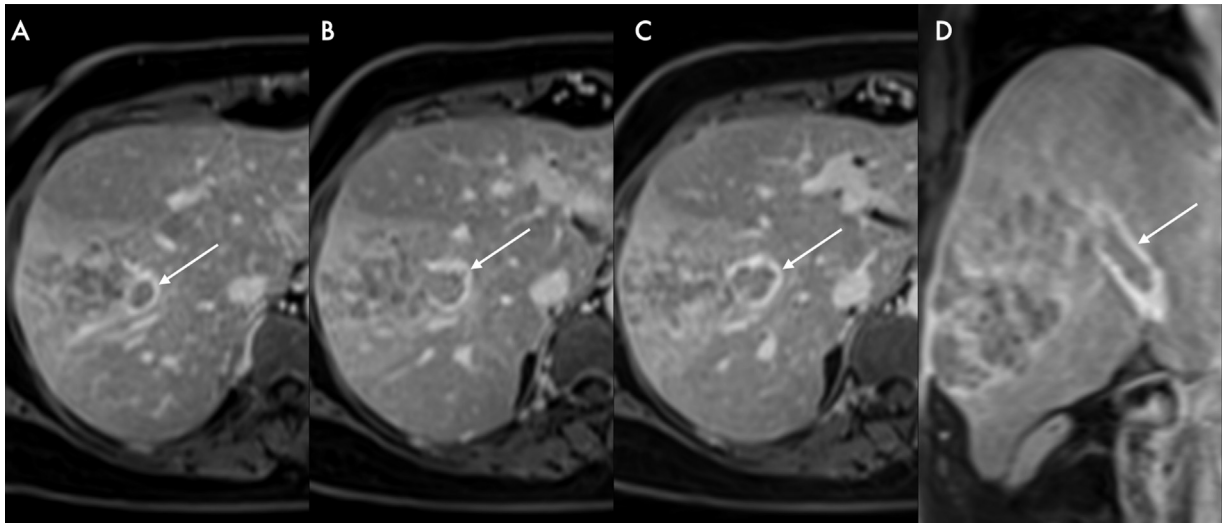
(A–D) LR-TIV: Magnetic resonance imaging venous phase axial (A–C) and coronal images (D) showing a large heterogeneously enhancing lesion in segment VIII (arrow) with definite enhancing soft tissue seen contiguously infiltrating into anterior branch of right portal vein and right portal vein consistent with tumor in vein (TIV).
